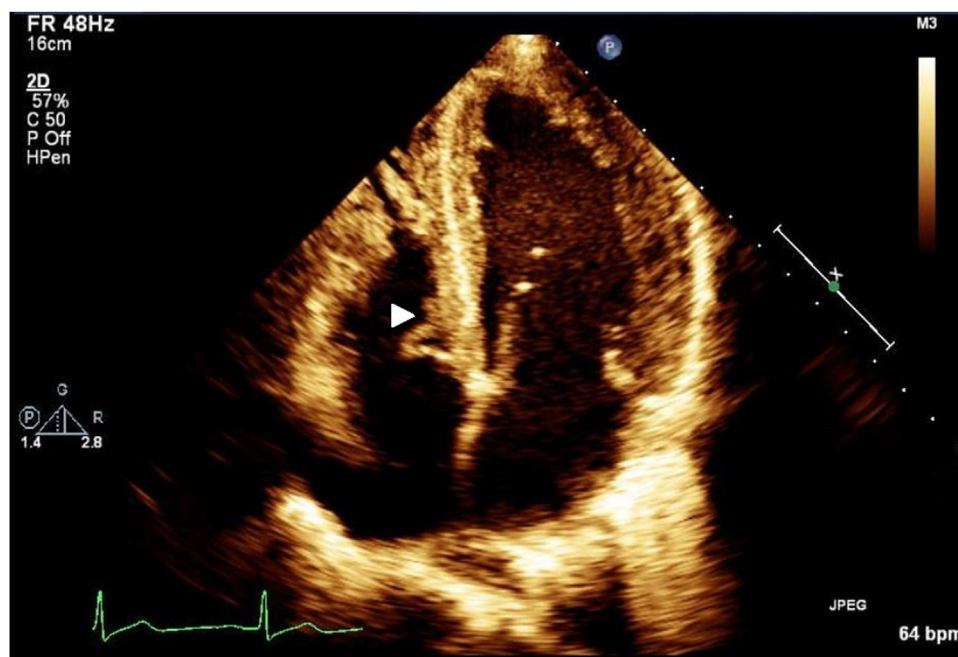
Transthoracic echocardiogram, apical 4-chamber view. White arrow points to vegetation on the septal leaflet of the tricuspid valve.
